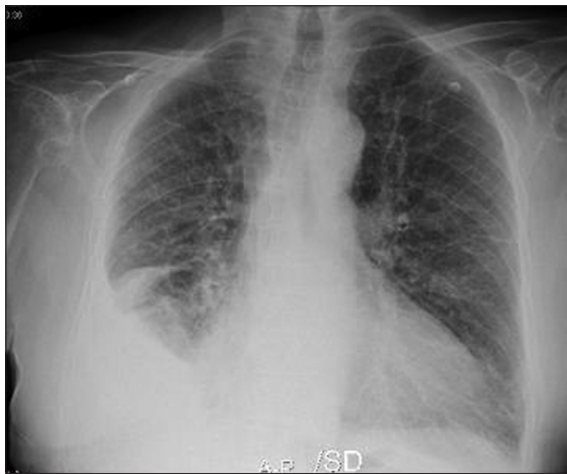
Chest radiography with right pleural effusion
